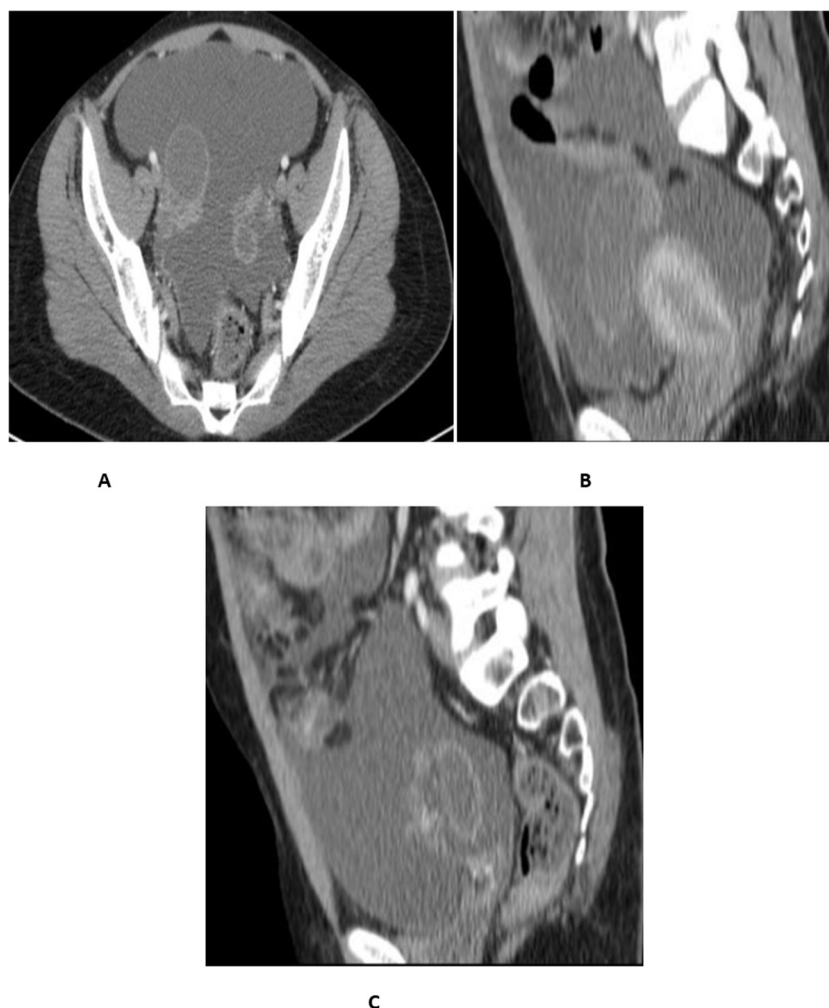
Abdomino-pelvic CT scan of the patient showing free peritoneal fluid collection and large (6 × 4 cm) right adnexal cystic mass with thick contrast enhancing wall and solid component (A – coronal view; and B – sagittal view). (C) 4 × 2 cm left adnexal cystic mass with thin wall and less solid component.
